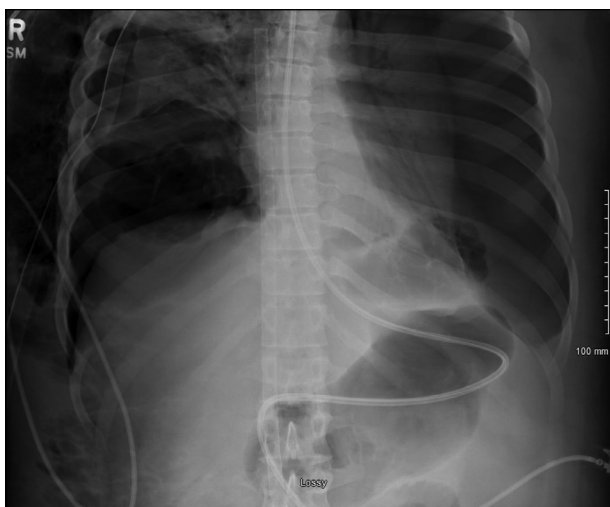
Chest radiograph showing large left pneumothorax.
